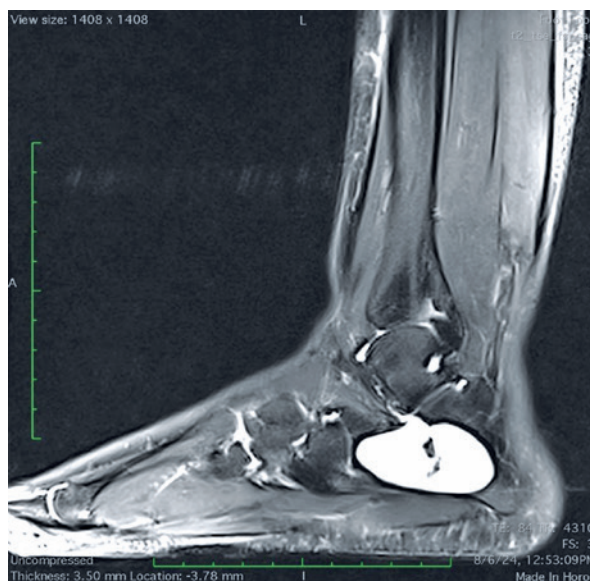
A magnetic resonance imaging with gadolinium contrast showing minimal marginal uptake and no fat tissue.
